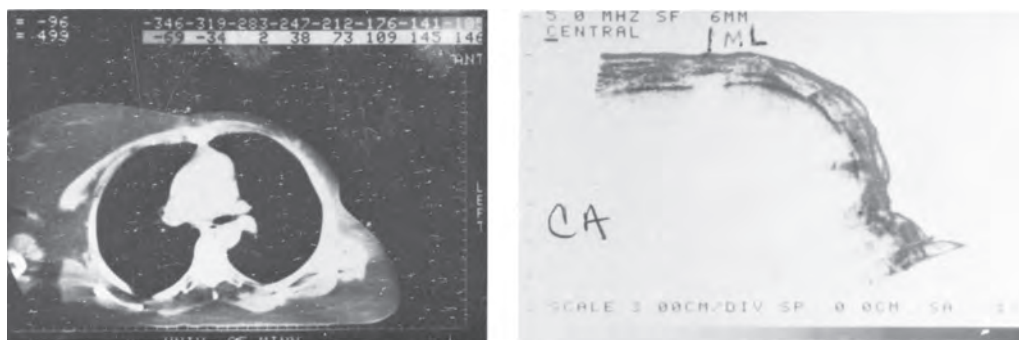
Ultrasonic tomogram showing chest wall thickness (*right*) compared with the computed tomography image (*left*).
